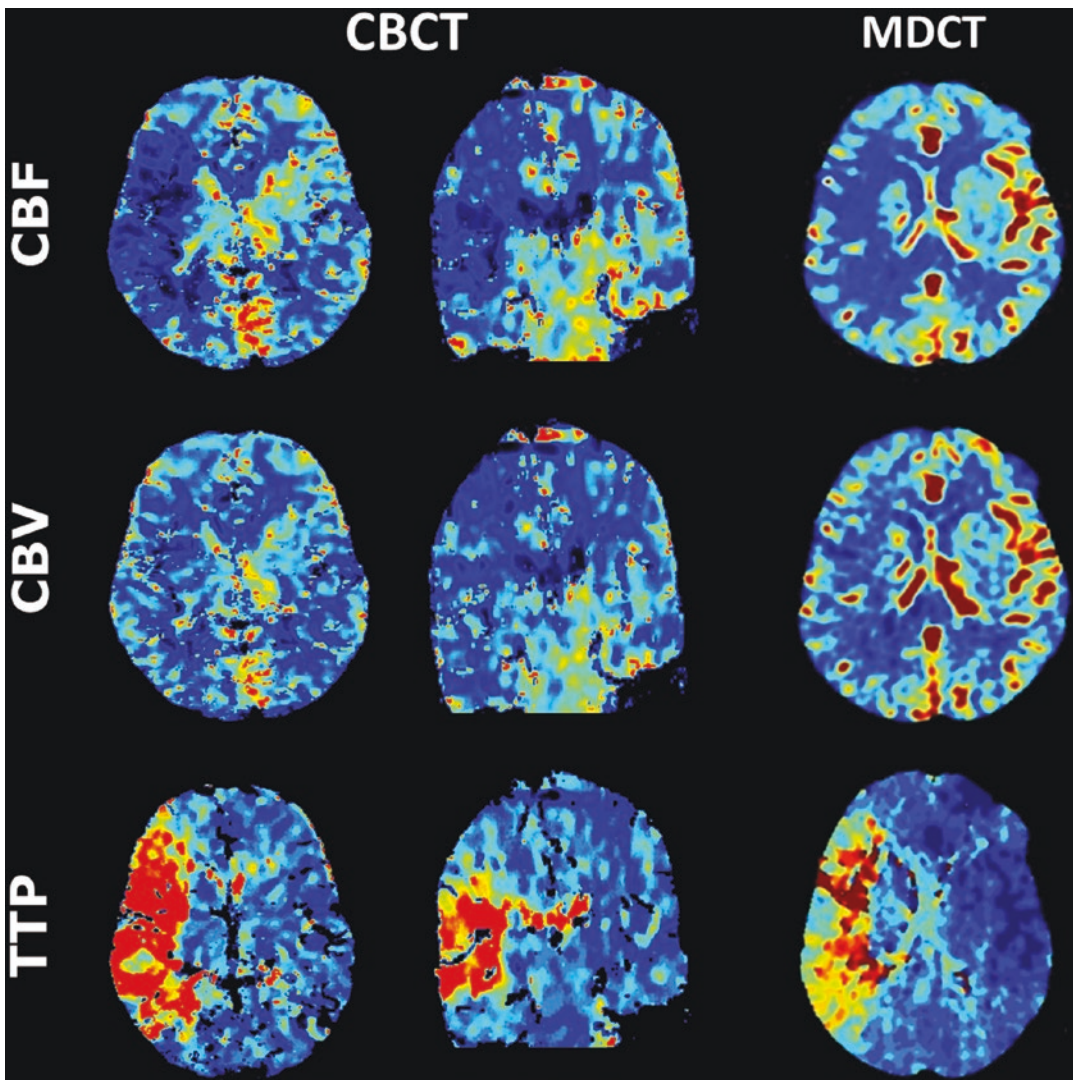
CBCTP and MDCTP maps showing perfusion abnormalities due to occlusion of the M1 segment of the right middle cerebral artery. There is a mismatch between
